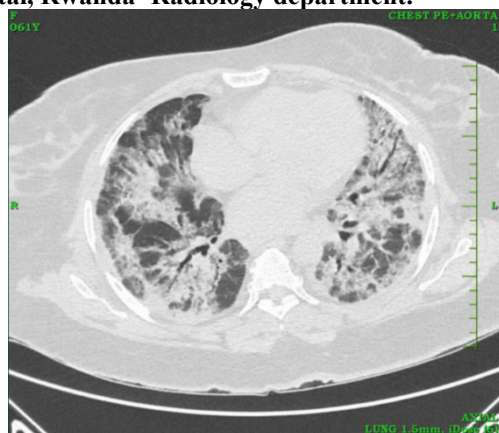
Axial CT scan, lung window with GGO and interlobular septal thickening/ crazy paving.
